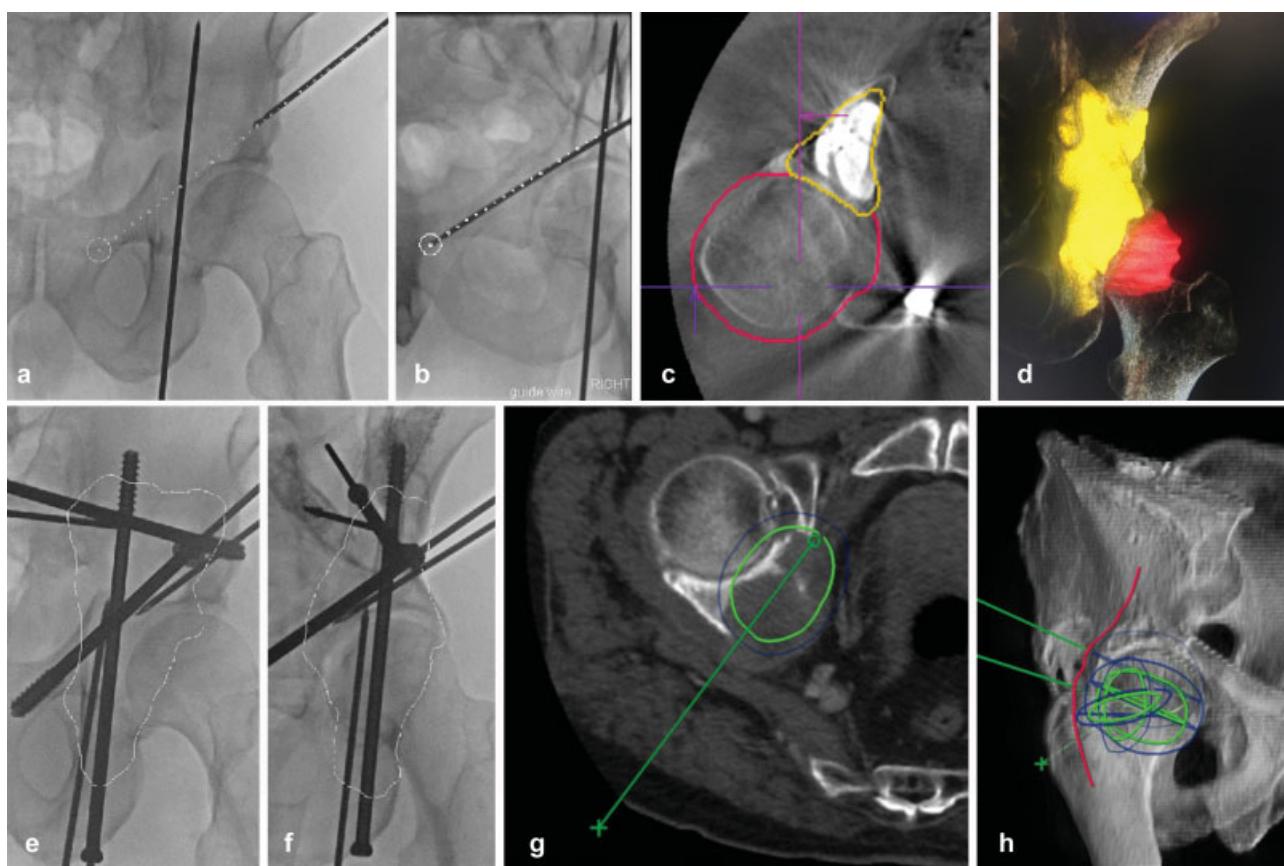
Examples of augmented fluoroscopy (AF): Needle guidance during placement of Steinman guide pins (a, b) over which cannulated screws will be placed. (c) Volumetric segmentation of lytic defect (yellow, filled with cement) and joint capsule (red) on intraoperative cone-beam CT (c) with corresponding volume rendering (d) and orthogonal contour outline of the yellow volume from different fluoroscopic projections (e, f). 3D objects used to estimate ablation zone (g) and visualize ablation overlapping ablation zones in relation to sciatic nerve (red, h).
